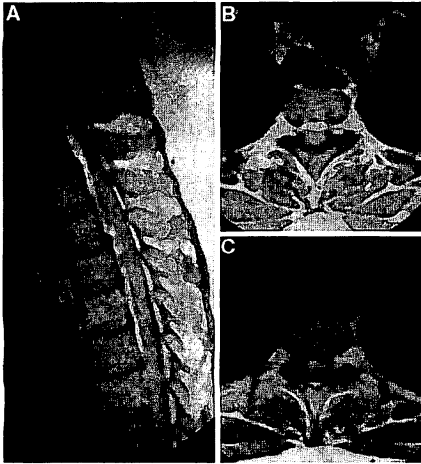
A, magnetic resonance images (T1-weighted spin-echo images at 0.5 T) of a 30-year-old woman. B and C, axial images of level T3. A and B, images obtained on Day 7, showing subarachnoid hematoma extending from level C7–T6 ventrally to the spinal cord. There is no severe compression of the cord. C, follow-up magnetic resonance images obtained on Day 29. No abnormality is revealed.
